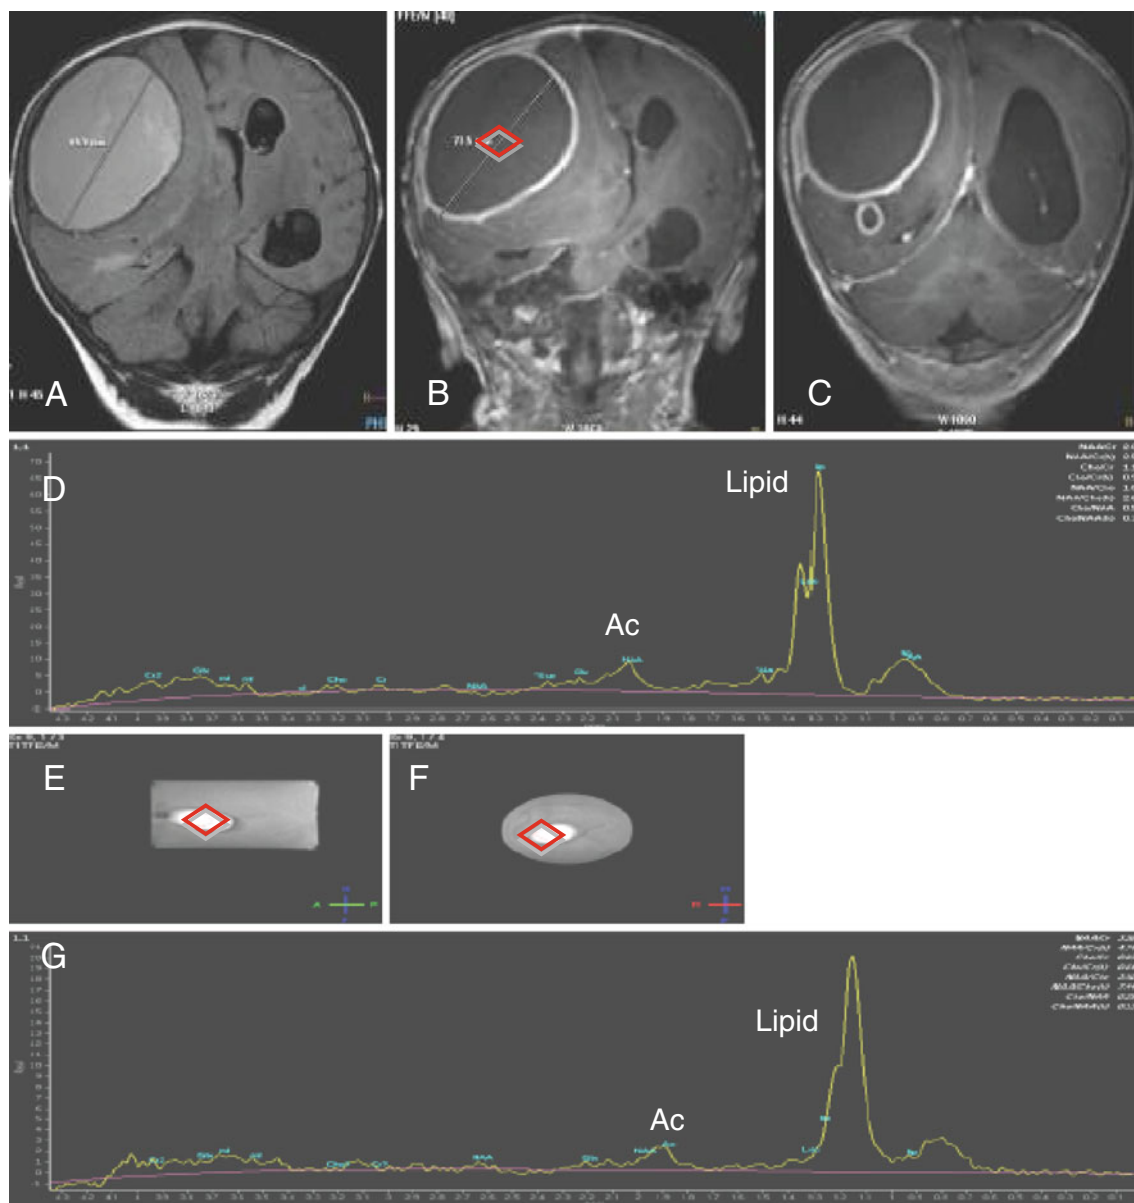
Brain MRI of a 9-month-old boy (case 1) and in vivo and in vitro ^1H -MRS of the pus from cerebral abscess. Coronal FLAIR (a) and coronal contrast-enhanced T1-weighted (b, c) MR images show a large fronto-parietal brain abscess and a small right parietal abscess. In vivo ^1H -MRS of the abscess center (d) shows a large partially overlapping lactate and lipid peak at 1.3 ppm, along with a small of acetate (Ac) peak at 1.9 ppm. Findings are compatible with a bacterial
